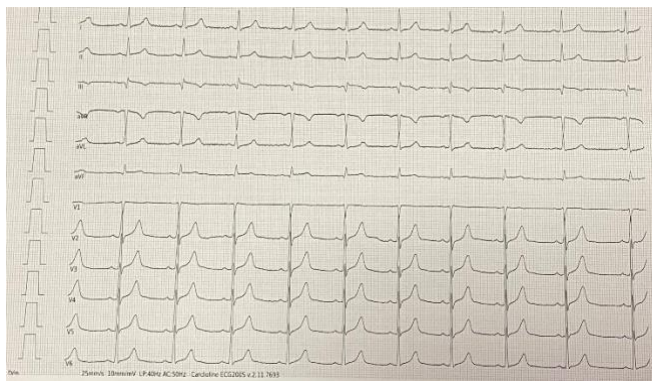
echocardiogram at admission .
